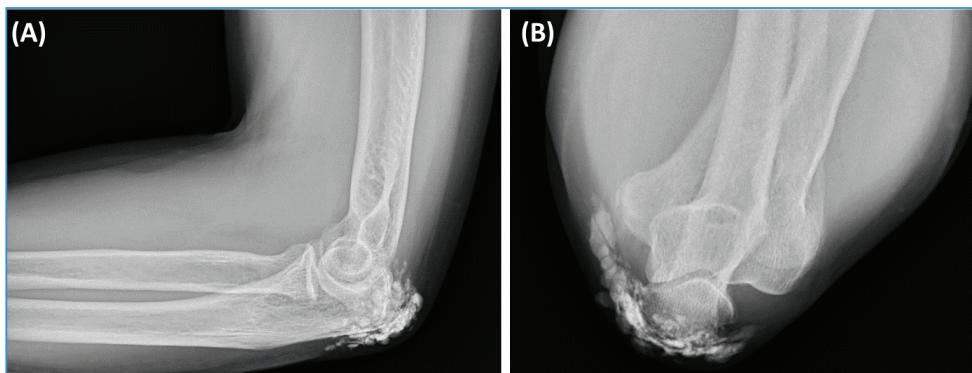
(A) X-ray of the left elbow, side view. (B) X-ray of the left elbow, axial view.
